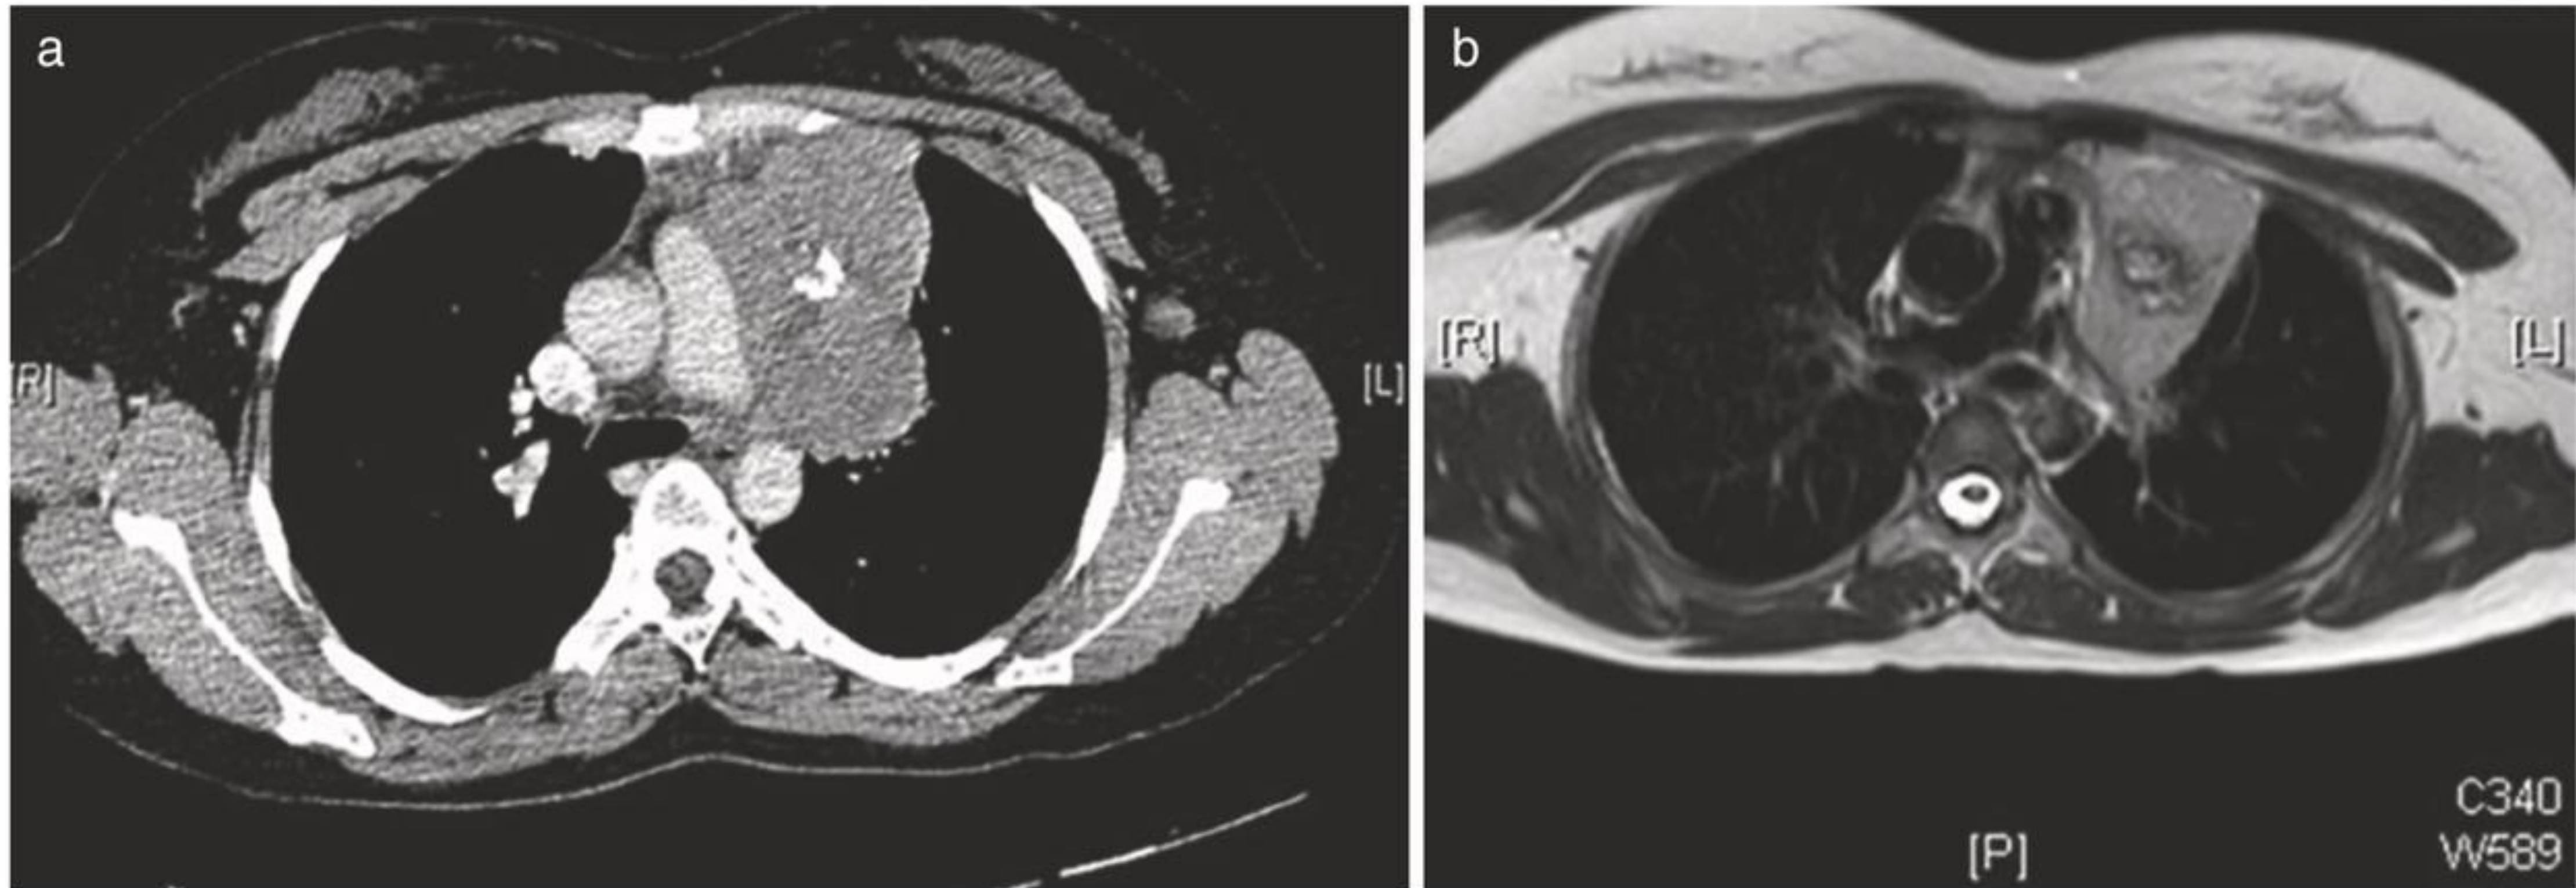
(a) CT scan of thymoma with suspected infiltration of pulmonary conus. (b) MRI shows no evidence of infiltration of pulmonary artery
